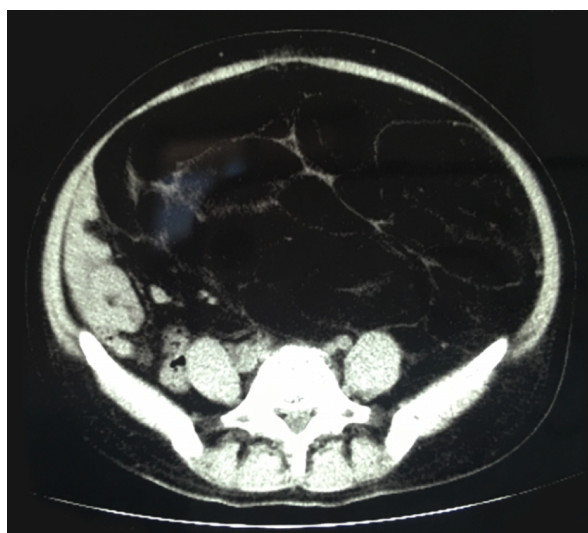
Abdominal computed tomography in the axial plane. Computed tomography imaging showed a giant homogenous mass, mainly consisting of fatty tissue measuring 16.6 cm × 28.6 cm with thin septa, pushing the peritoneal containing such as bowel loops and uterus to the right part of abdomen.
